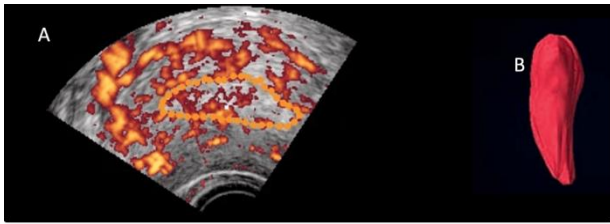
(A) Assessment of endometrial receptivity; 3D volume box is placed along the endometrial cavity; (B) 3D ultrasound and 3D power doppler can calculate endometrial volume, and endometrial and sub-endometrial vascularity, respectively (B).
